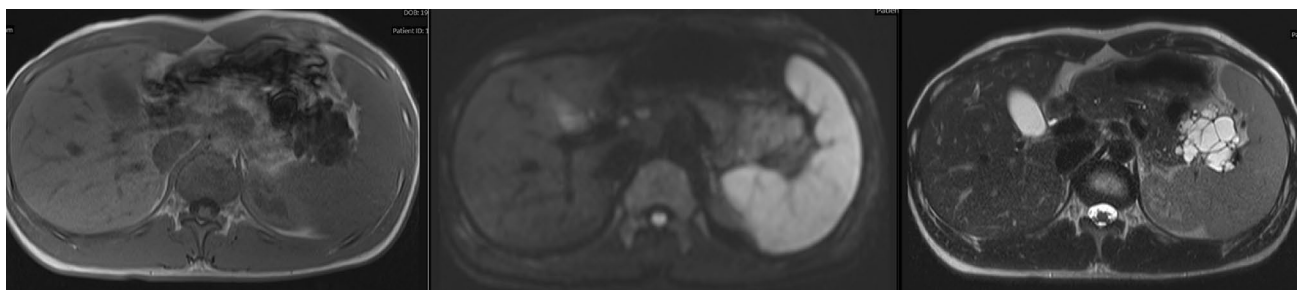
Magnetic resonance imaging (MRI) revealed a few dilated lumens within the pancreatic tail, as well as cysts of various sizes located within a larger cyst. Enhancement was not observed in the cyst wall, and dilation of the main pancreatic duct was not detected.
